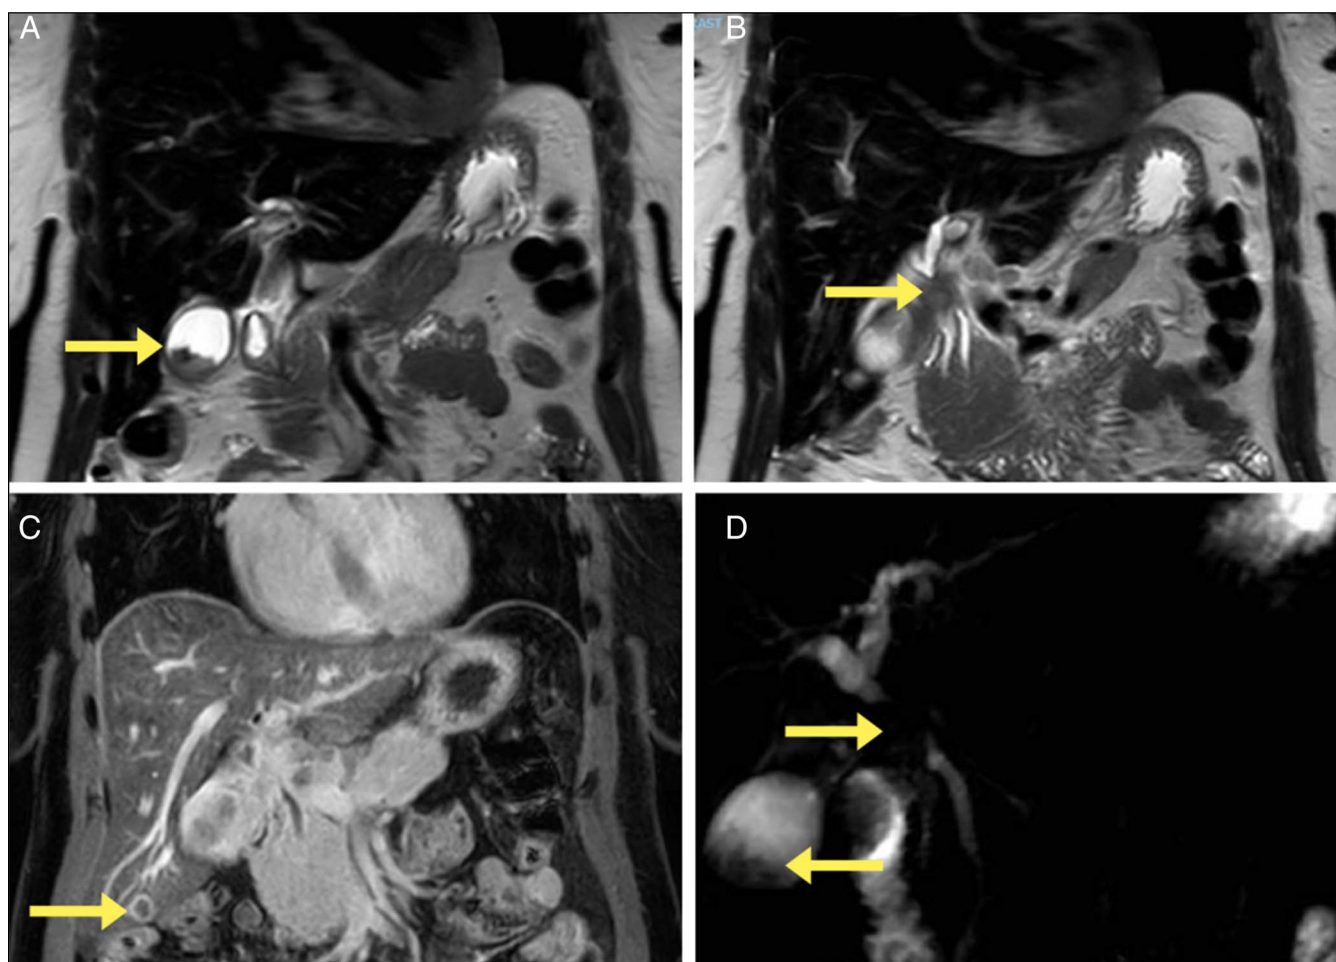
(A) Coronal MRI highlighting gallbladder mass (arrow). (B) Coronal MRI highlighting biliary stricture (arrow). (C) Coronal MRI demonstrating liver mass (arrow). (D) Magnetic resonance cholangiopancreatography sequence with both mass and stricture. MRI, magnetic resonance imaging.
